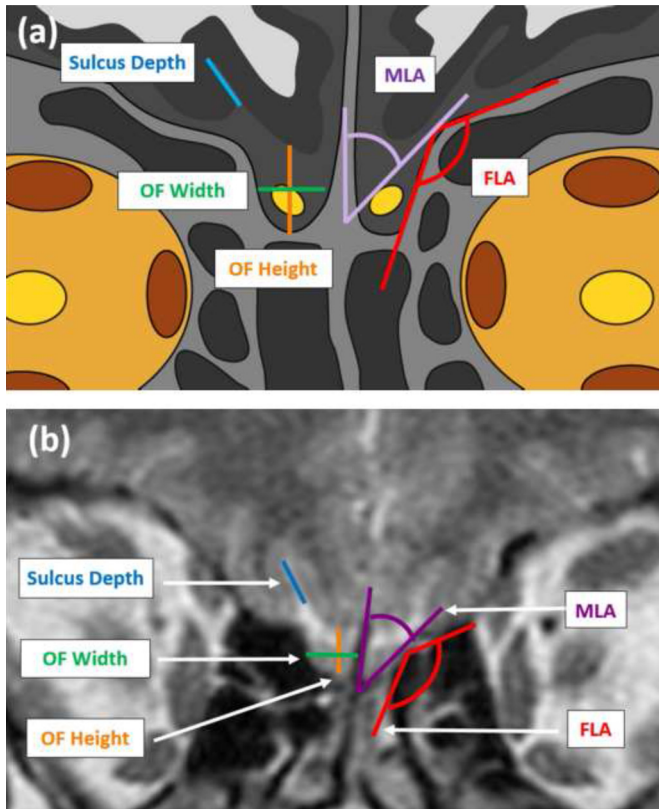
a: coronal image of the olfactory region. This representation shows the MLA (angle between midline and junction between fovea ethmoidalis and lamella lateralis), FLA (angle between fovea ethmoidalis and lamella lateralis), OF height (distance between cribriform plate and fovea ethmoidalis plane), OF width (distance between midline and mid part of lamella lateralis) and sulcus depth (distance between gyrus rectus and orbital medial gyrus); b: coronal-T2-weighted MR image of a digital slice through the olfactory bulb. Representation shows the MLA (angle between midline and junction between fovea ethmoidalis and lamella lateralis), FLA (angle between fovea ethmoidalis and lamella lateralis), OF height (distance between cribriform plate and fovea ethmoidalis plane), OF width (distance between midline and mid part of lamella lateralis) and the sulcus depth (distance between gyrus rectus and orbital medial gyrus).
